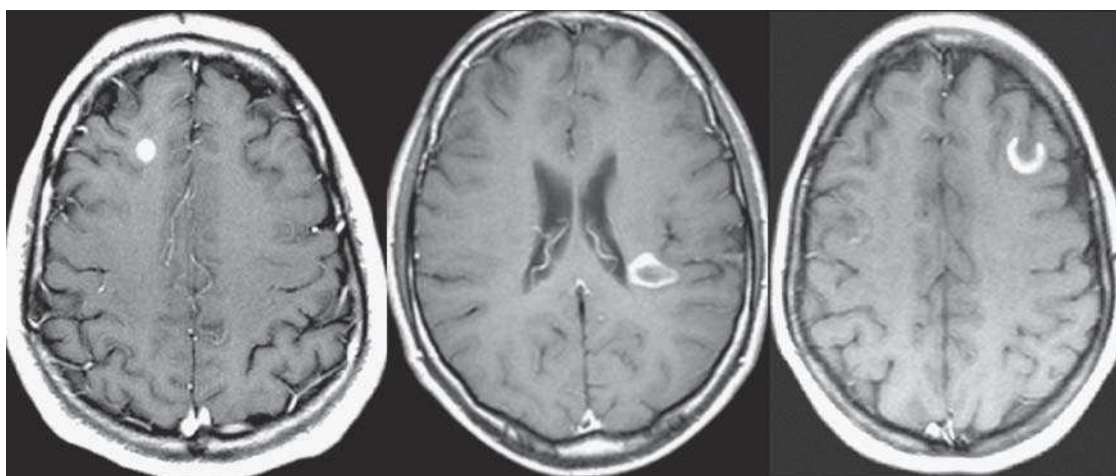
Brain magnetic resonance imaging (post-contrast T1-weighted sequences) in 3 different patients showing lesions with inflammatory activity. Note the different types of enhancement: nodular (left), ring (centre) and incomplete ring (right). The last enhancement pattern is very characteristic of inflammatory-demyelinating lesions.
